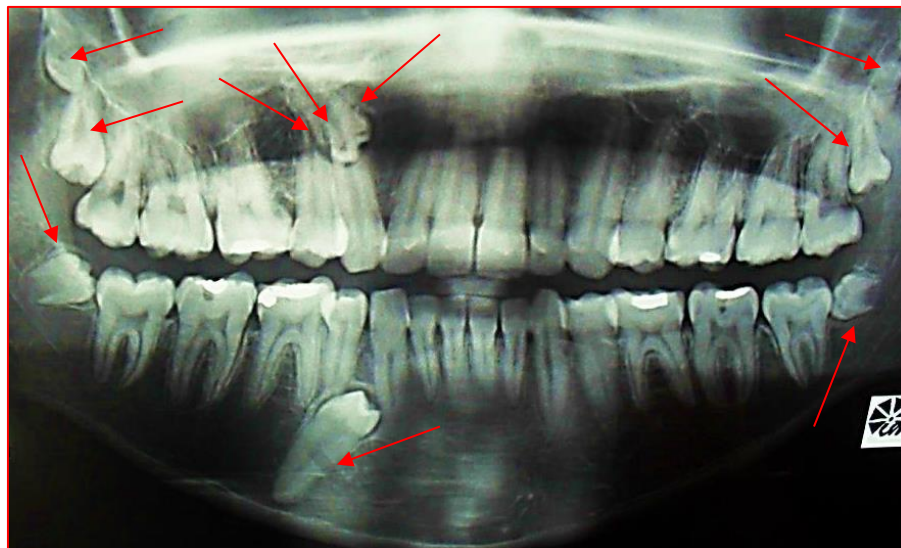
Supernumerary teeth and retained in a panoramic radiograph.
